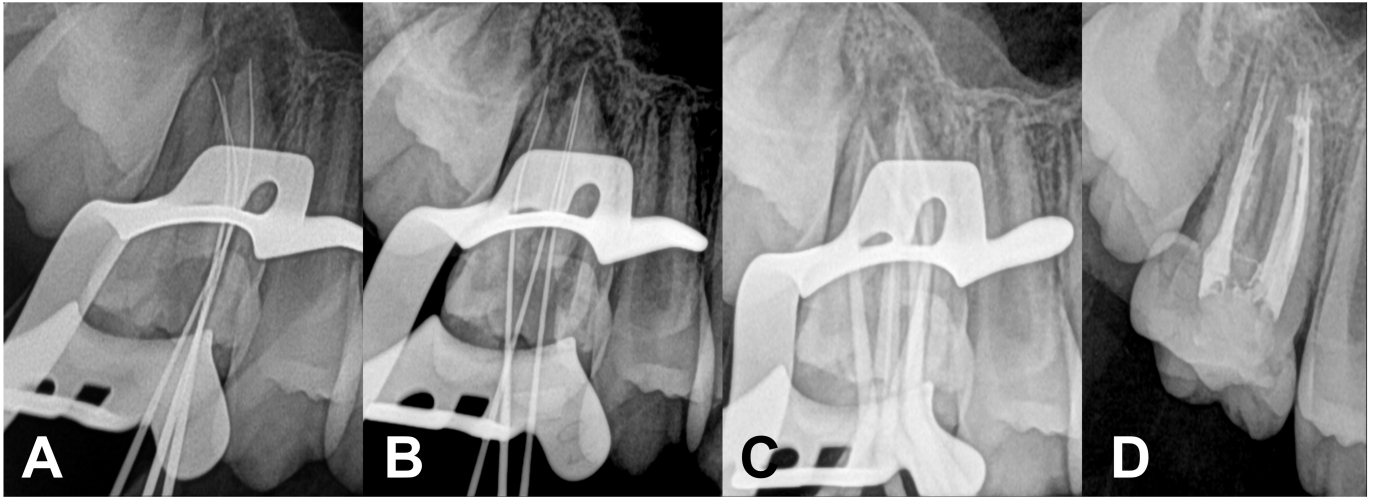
Serial periapical radiographs taken during root canal treatment. (A) Working length determination radiograph using a #15 K-file. (B) Working length determination radiograph using a #15 K-file. (C) Master cone filling radiograph. (D) Post-obturation (canal filling and core restoration).
